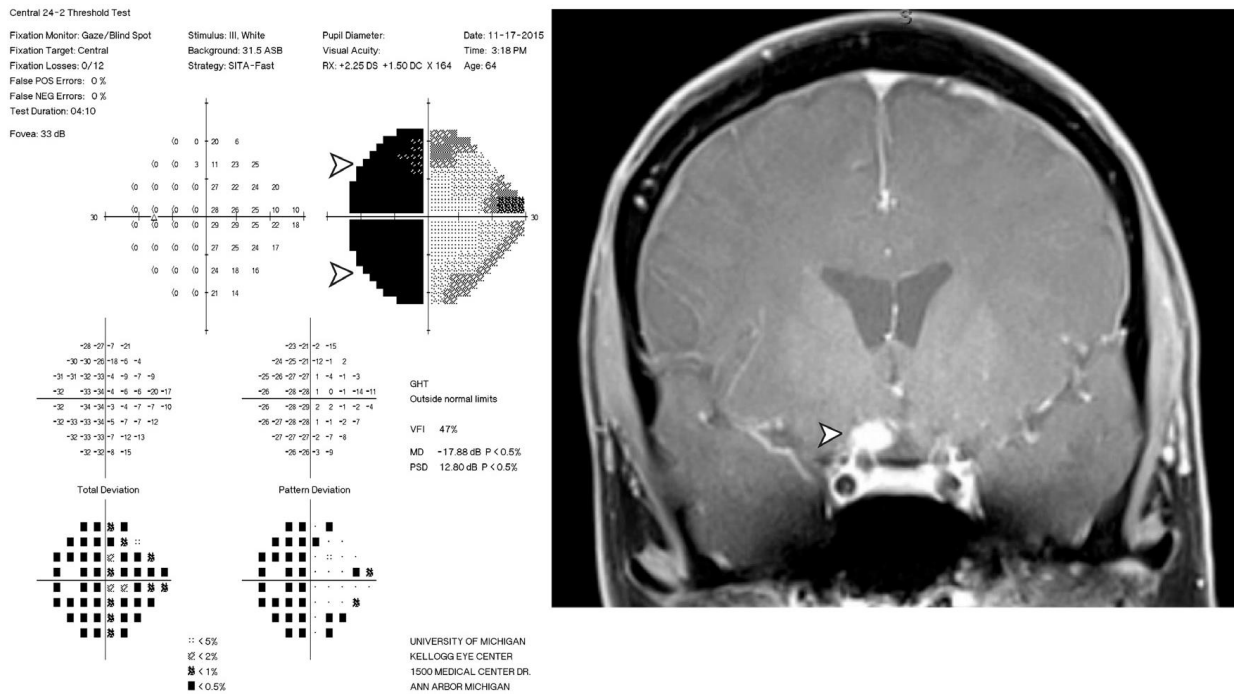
Functional and structural cause of vision loss in Case 103. Two years following negative cytology results from intraocular liquid biopsies in each eye, the patient developed severe vision loss in the left eye. A. Humphrey 24-2 visual field testing report of the left eye revealed a dense temporal hemianopia, denoted by black area (arrowheads), which signified lack of sensitivity to light stimulus in the temporal half of visual field. B. Magnetic resonance imaging with gadolinium contrast revealed an enhancing lesion abutting the right optic chiasm and optic nerve. Subsequent cytological analysis
